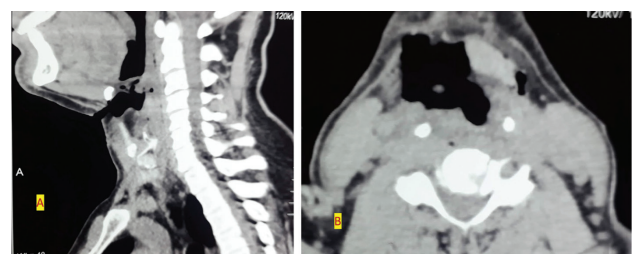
(A) CT sagittal and (B) CT axial view showing the extension of cut injury and its connection with laryngopharynx
